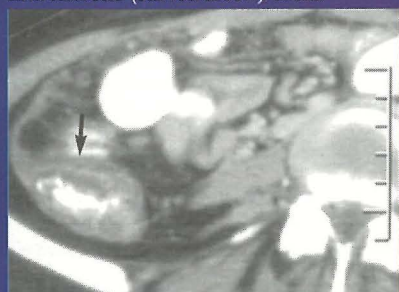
CT scan showing tuberculous nephritis with gross parenchymal destruction and intra (straight arrow) and extra-parenchymal (curved arrow) abscesses.
